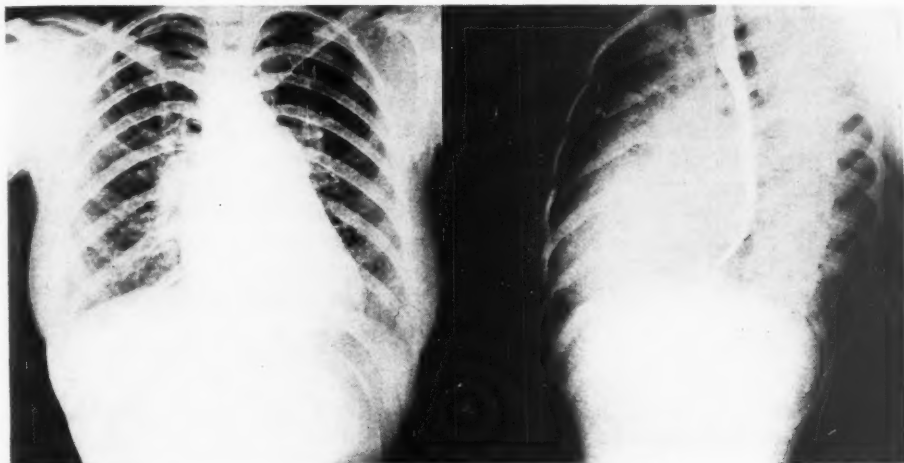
Anteroposterior and right anterior oblique preoperative roentgenograms showing size of heart and left auricle (Case 1).
